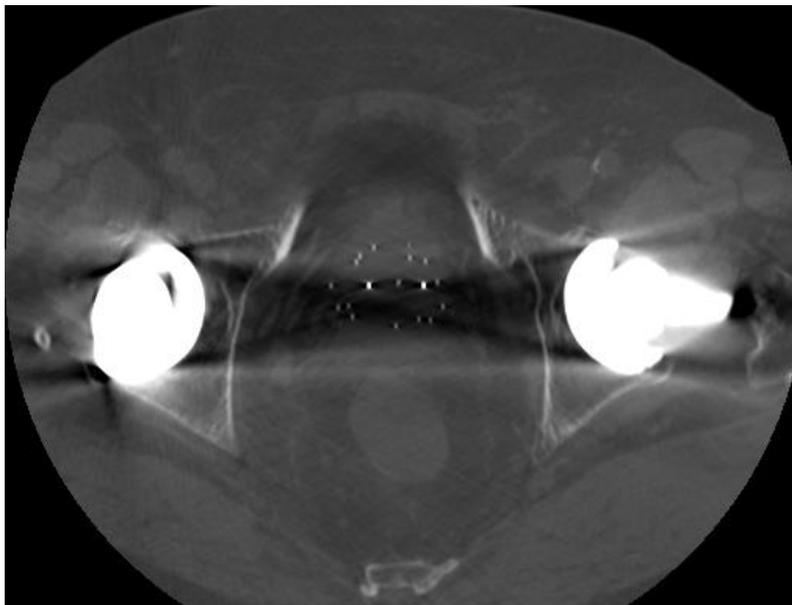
CT slice from bilateral hip HDR prostate brachytherapy patient at SCGH (GE Lightspeed VCT, 140 keV, auto mAs. FOV 302x302 mm, 512x512 array, 16 bit grey-scale, 0.625 mm slice, 'soft tissue' filter). Slice shows hip prostheses and associated artifact, and implanted needle markers. Fiducial markers visible as brighter spots near image centre.
